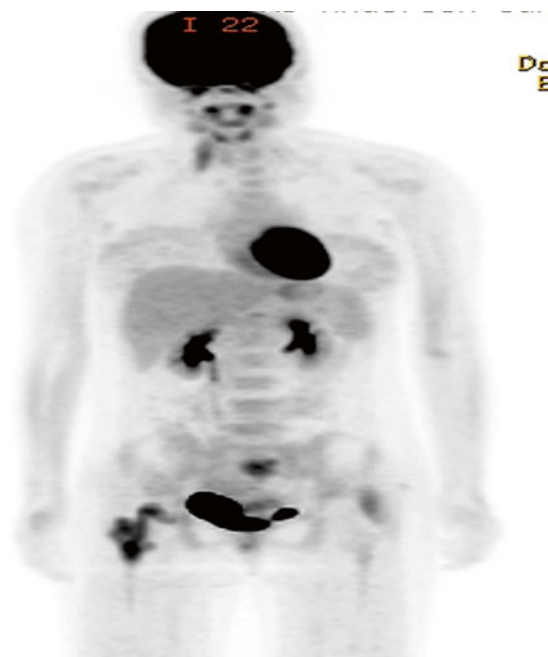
A 18 year-old girl presented with metastatic alveolar RMS. PET CT showed multiple metabolically active sites of metastases including a metastasis in the right proximal femur with extension into the surrounding soft tissues
